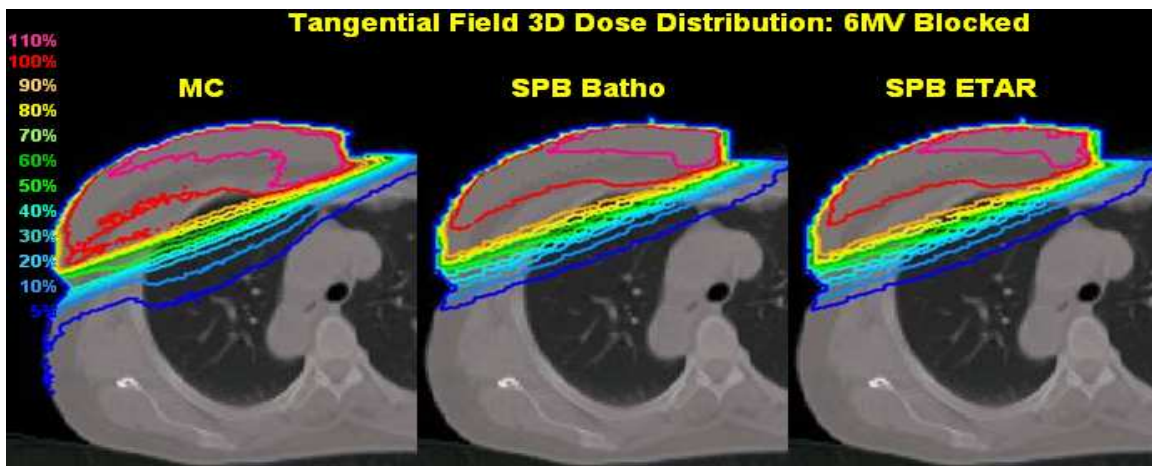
Comparison of the dose distributions from both partially blocked tangential fields for the 6 MV breast case. Dose volume histograms were calculated from this data. The ICRU reference point was situated on a different CT slice.
